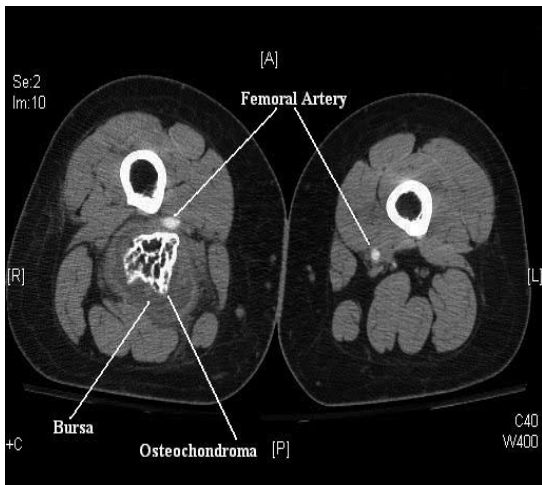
The CT angiogram showing a large bursa around the tumor. CT - computed tomography.
